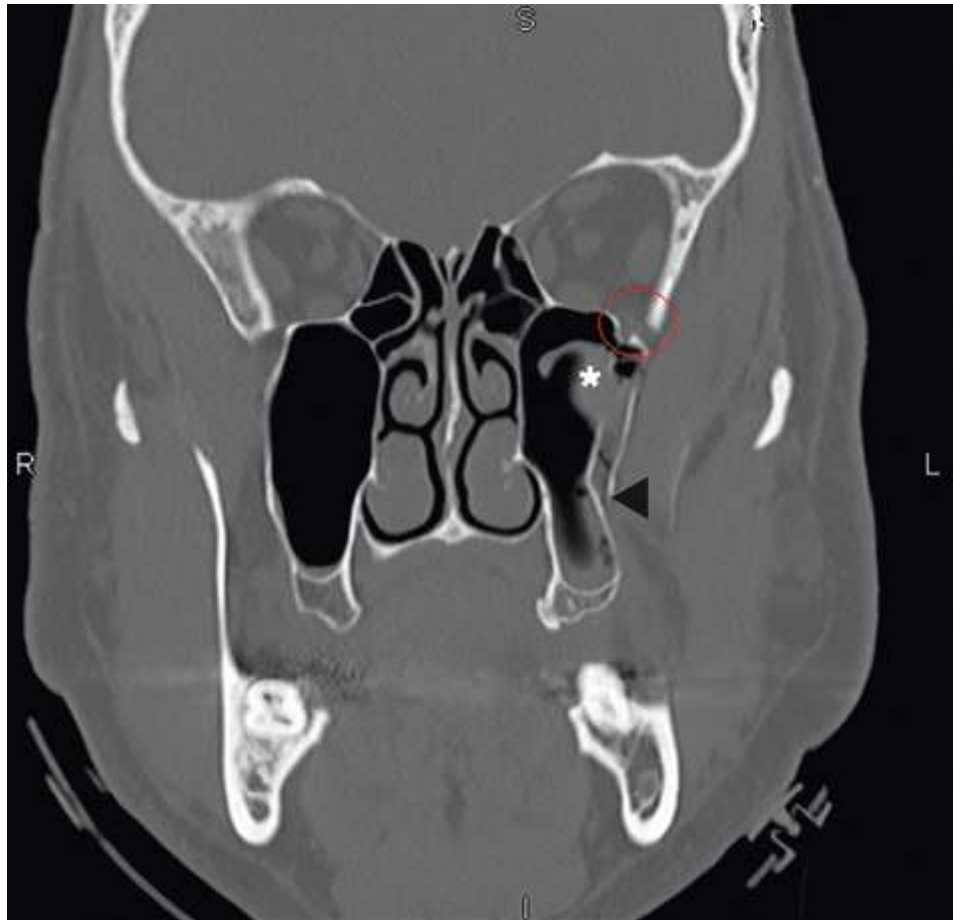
Coronal CT of complex blowout fracture, zygoma fracture (*red circle*), and additional maxilla fracture (*arrowhead*). Associated blood/soft tissue in maxillary sinus (*). Courtesy Priscilla Rounds, RT[R], NEA Baptist Memorial Hospital, Jonesboro, AR.
